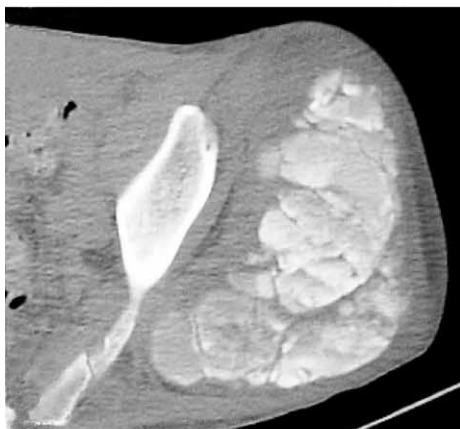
(a) Left shoulder mass. (b) Plain radiography and (c) computed tomography of the left shoulder reveal extensive periarticular soft-tissue calcification, without evidence of bony involvement.
